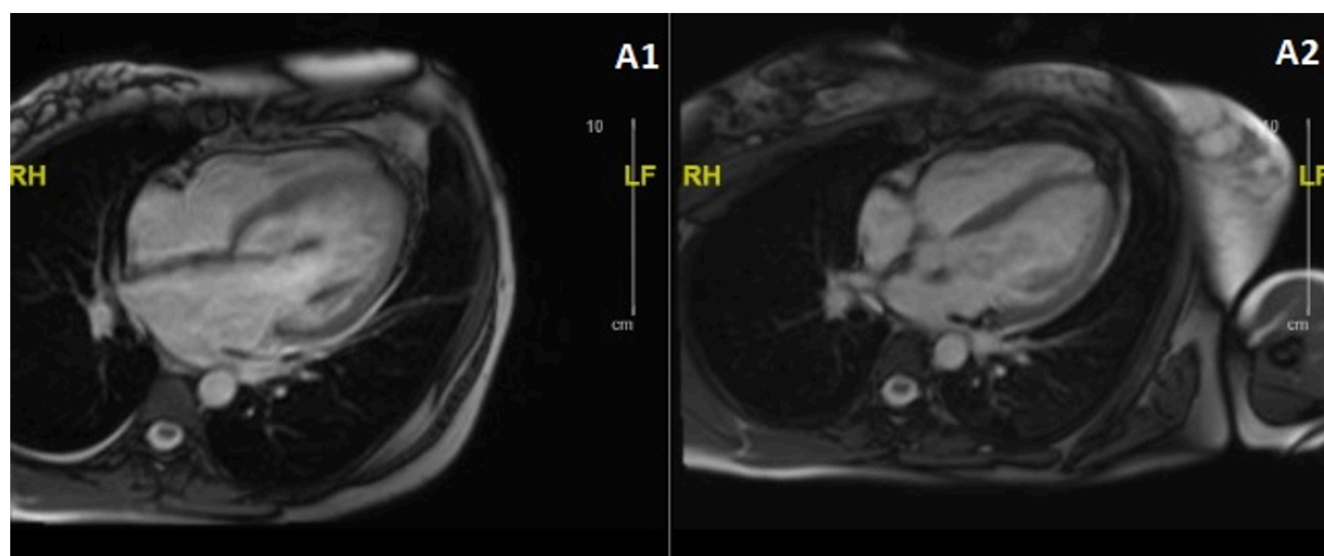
Cardiac magnetic resonance imaging findings show normalization in left heart size A1: at admission, A2: 6 months of follow-up
